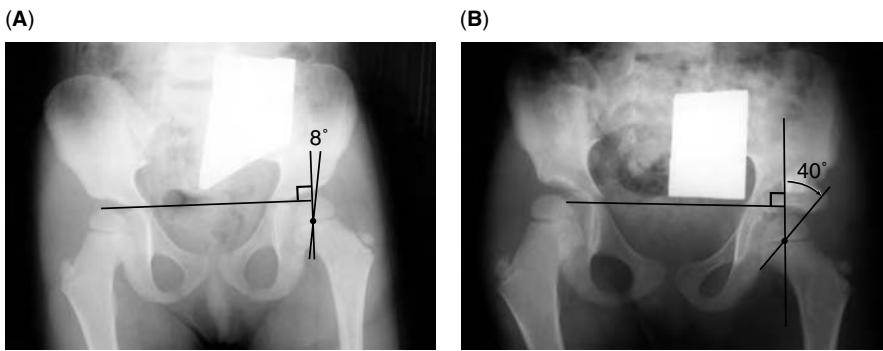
(A) Three-year-old female patient with Paley Type 1a congenital femoral deficiency and concurrent right hip dysplasia shown by the diagonal acetabular sourcil and a center edge angle of 8° (left center edge angle = 25°). (B) Postoperative radiograph after Dega osteotomy shows corrected dysplastic acetabulum.
